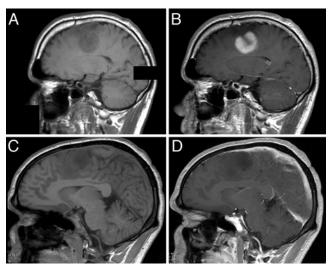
Precontrast (A and C) and postcontrast (B and D) administration T1-weighted MR images demonstrating representative patients with a contrast-enhancing (A and B) and nonenhancing (C and D) AA. The AA is left frontal in the first patient (A and B), and right frontal in the second patient (C and D).
